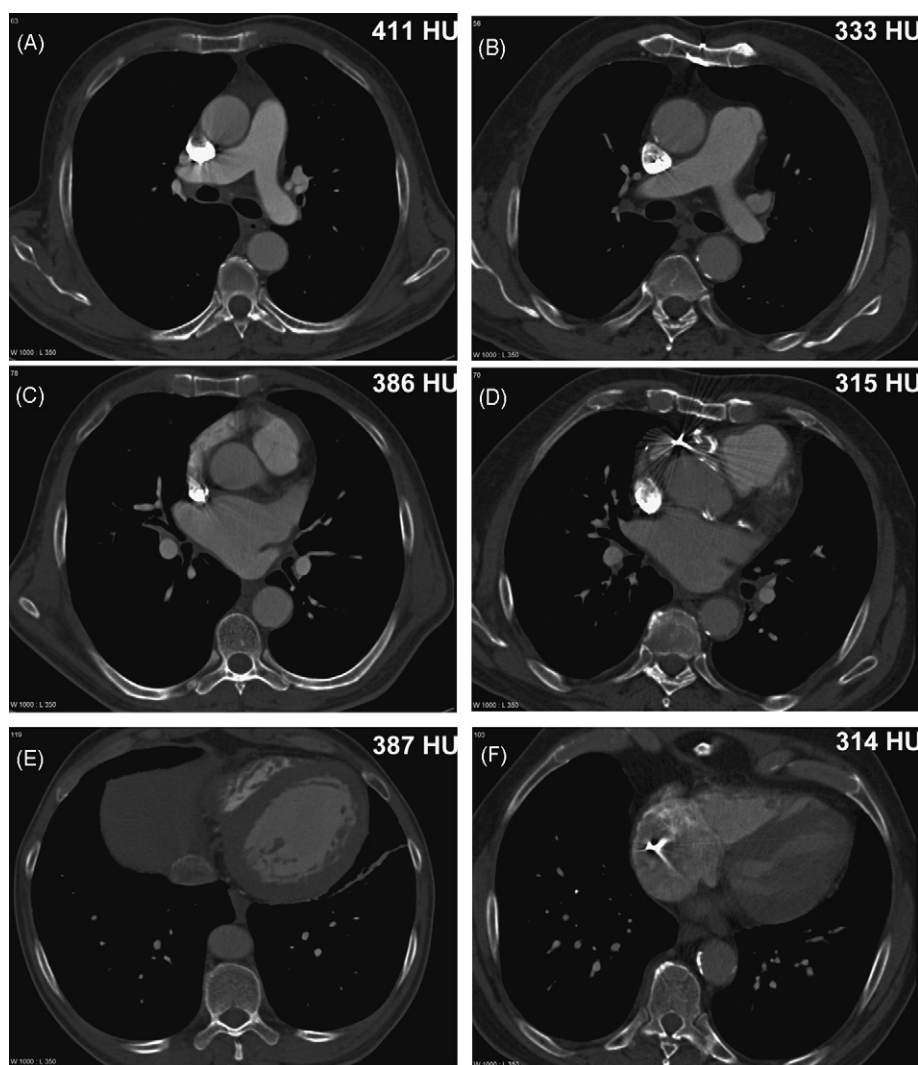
CTA of the main pulmonary artery and right/left pulmonary arteries (A and B), lower lobe arteries (C and D), and segmental/subsegmental pulmonary branches (E and F) acquired on a four-slice CT scanner (CTA windowing: W 1000/L 350) after iomeprol 400 (A, C, E; left column) and iodixanol 320 (B, D, F; right column). Consistently greater contrast density was achieved with iomeprol 400 compared to iodixanol 320 in each vessel. Image sets with contrast densities closest to the average density values are demonstrated (411 vs. 333 HU for the main pulmonary artery, 386 vs. 315 HU for the left pulmonary artery, and 387 vs. 314 HU for the left lower lobe artery).
